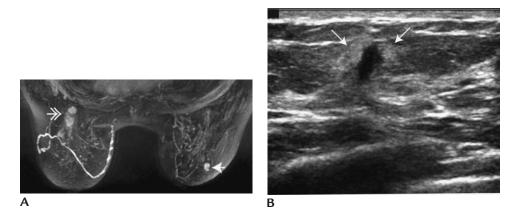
Evaluation of patient with newly diagnosed invasive ductal carcinoma in the left breast. (A) Maximum intensity projection. Patient with known, biopsy proven, invasive ductal carcinoma in the left breast (*double headed arrow*). Enhancing mass (*arrow*) identified anteriorly in the right breast. (B) Markedly hypoechoic, vertically oriented mass (*arrows*) with echogenic rim identified with ultrasound at the expected location of the MR finding. Invasive ductal carcinoma on ultrasound-guided biopsy.
